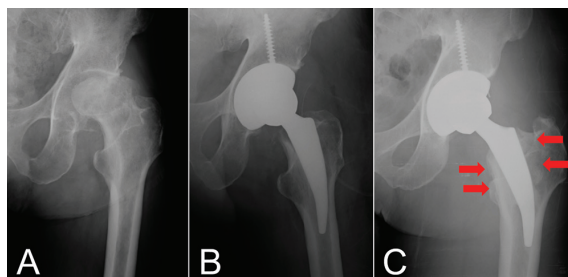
Anteroposterior radiograph of Metha[®] short stem prosthesis showed bone trabeculae development at 24 months postoperatively (C) compared to initial postoperative (B) and preoperative (A).
